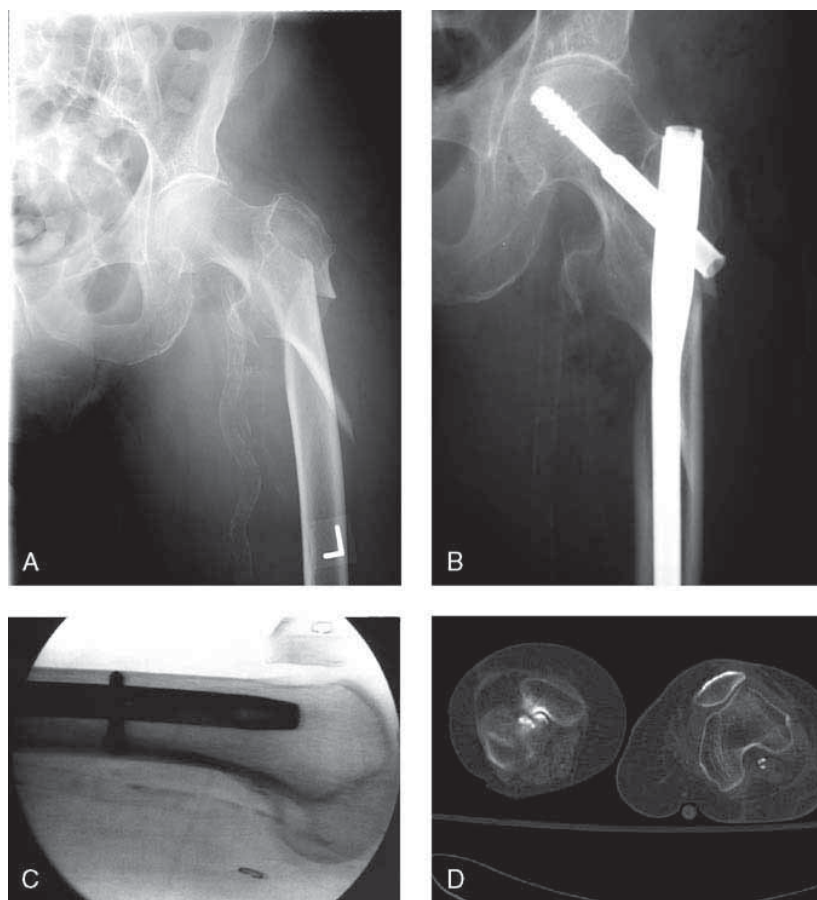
A, Preoperative AP radiograph of the proximal femur showing a comminuted intertrochanteric-subtrochanteric femoral fracture in a 90-year-old woman. B, Postoperative AP radiograph. C, Postoperative lateral radiograph of the distal shaft; a long intramedullary locked nail device is shown. D, Malrotation was noted clinically and confirmed with a postoperative CT scanogram.
